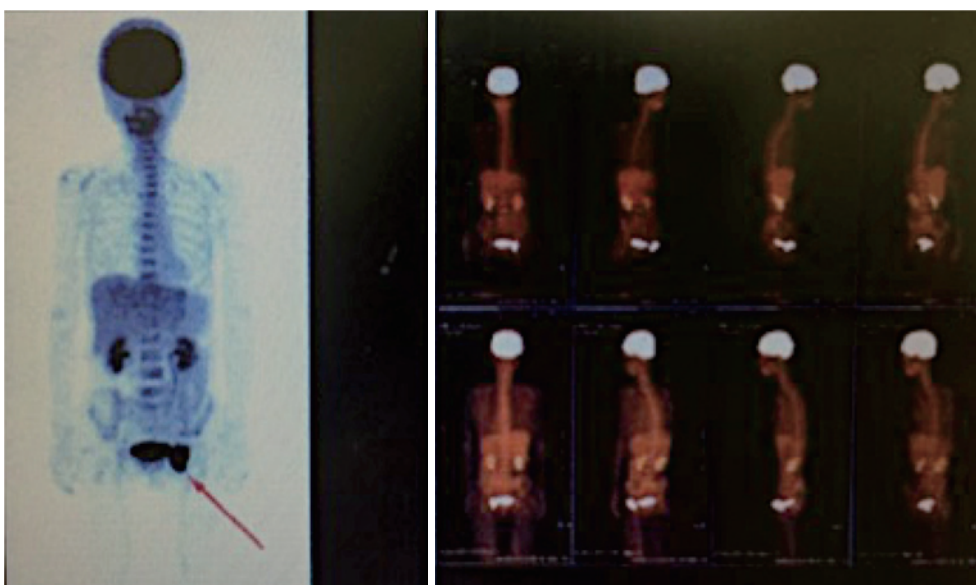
PET-CT image showing abnormal accumulation of FDG in the left inguinal region. No accumulation was observed in other parts of the body.
